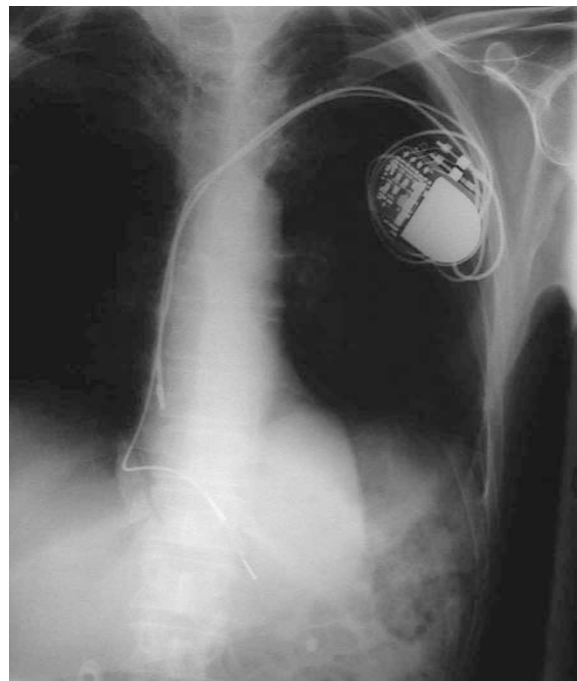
Chest X-ray shows cardiac pacemaker in the left pectoral region
